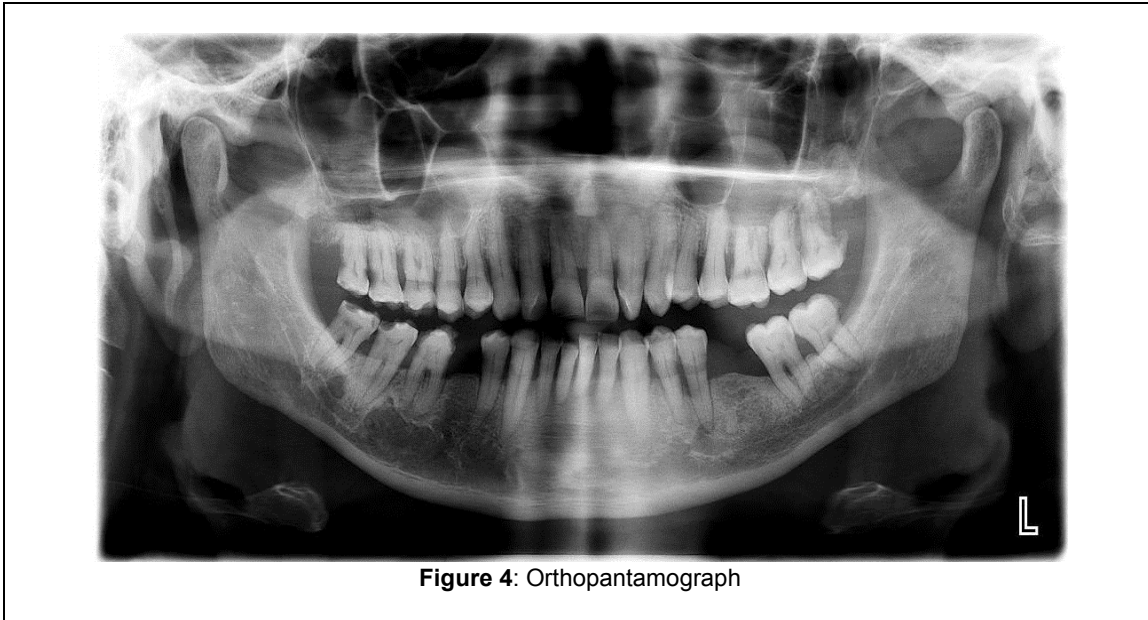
Orthopantomograph
